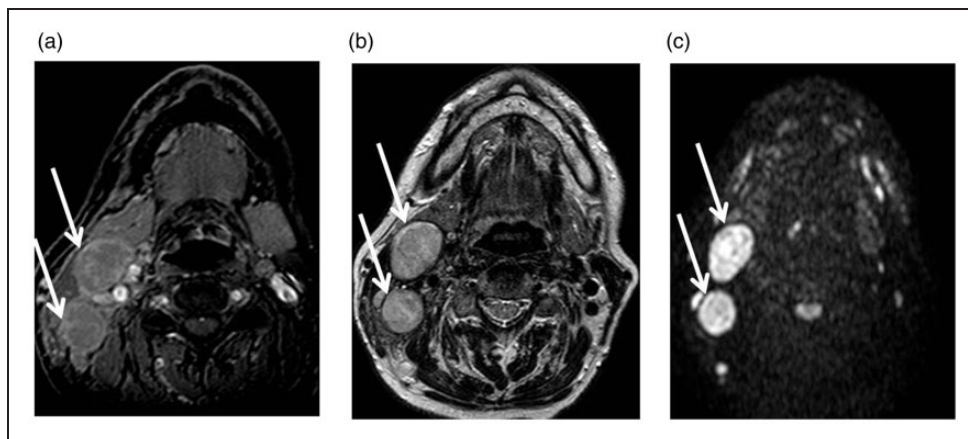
Axial magnetic resonance images obtained in a 66-year-old man with subglottic squamous cell carcinoma (SCC) and enlarged lymph node metastases in the level IIa and b on the right side. (a) On T2-weighted turbo spin echo (TSE) image, lymph node metastases (arrows) show heterogeneous hyperintensity. (b) On b800 diffusion-weighted image lymph node metastases show strong hyperintensity. (c) On contrast-enhanced T1-gradient echo (GRE) image lymph node metastases show heterogeneous enhancement.
